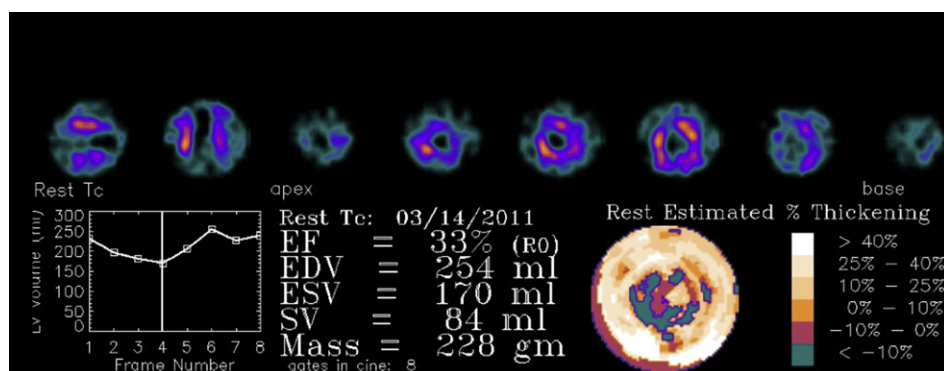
Single-photon emission computed tomography showing reduced ejection fraction and ischemic changes. EF = ejection fraction; EDV = end diastolic volume; ESV = end systolic volume; SV = stroke volume.
